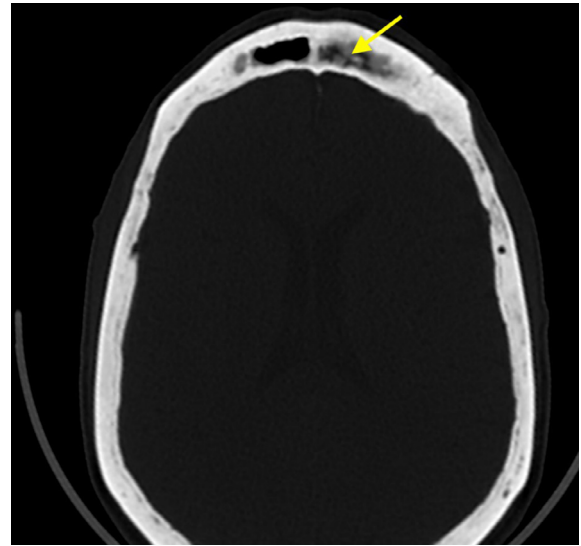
A 53-year-old male patient with Erdheim Chester disease. CT scan of the brain in the bone window showing sinus osteosclerosis (yellow arrow).
